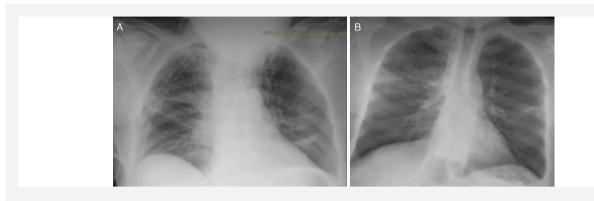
A) Chest radiography on the first day after surgery. B) Chest radiography on the second week after surgery
